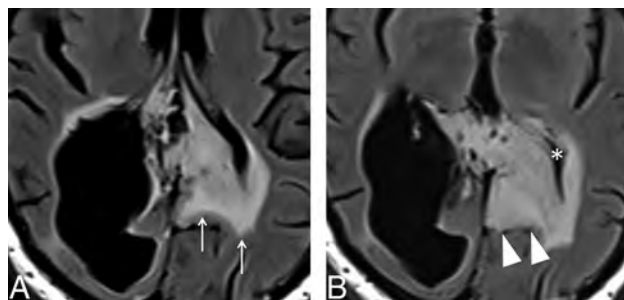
Imaging features of the nonenhancing component of glial tumors. A 36-year-old man underwent partial resection and adjuvant radiation therapy of an extensive diffuse astrocytoma (World Health Organization, grade II) involving both parietal lobes (not shown). A, Axial FLAIR image obtained 5 years after completion of radiation therapy demonstrates extensive hyperintensity crossing the midline through the splenium of the corpus callosum (arrows), probably representing a mixture of lower-grade tumor and radiation injury. B, Axial FLAIR image obtained 8 months later depicts blurring of the gray-white matter in the left parietal lobe (arrowheads), as well as effacement of the left lateral ventricle (asterisk), which is consistent with neoplastic infiltration (progressive disease).
